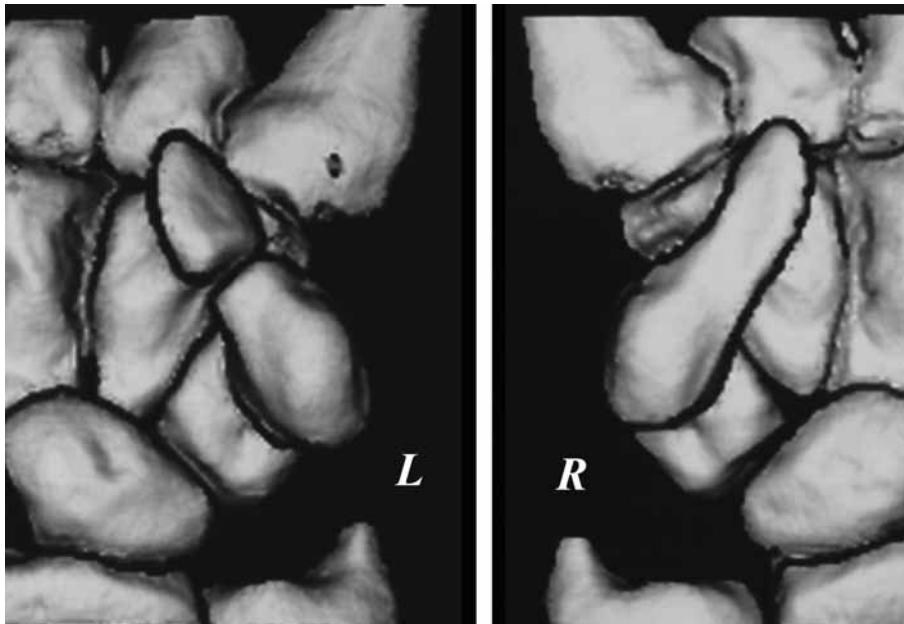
3D-reconstruction view of the anterior aspect of both wrists preoperatively, based on CT-scan cuts. On the right side, the coalition took the form of a continuous osseous bar.
